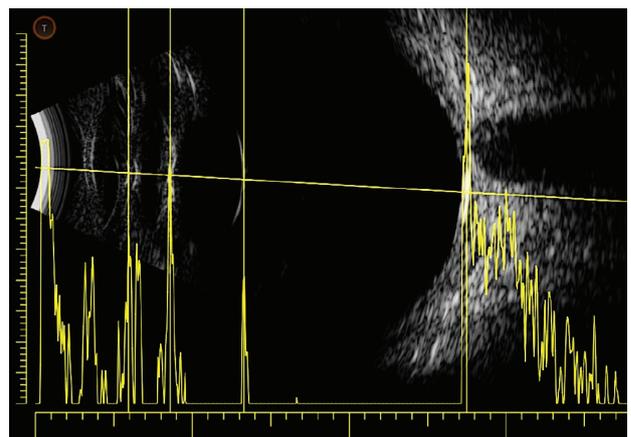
Calliper positioning selecting intra-ocular segment with various ultrasound speed : Cornea and ACD: 1532m/s, Lens: 1641m/s, Vitreous : 1532 m/s.
